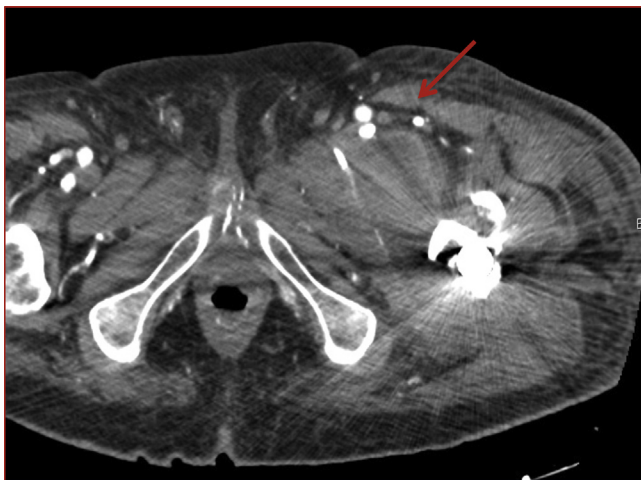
Contrast CT scan with no PSA after treatment (red arrow).
